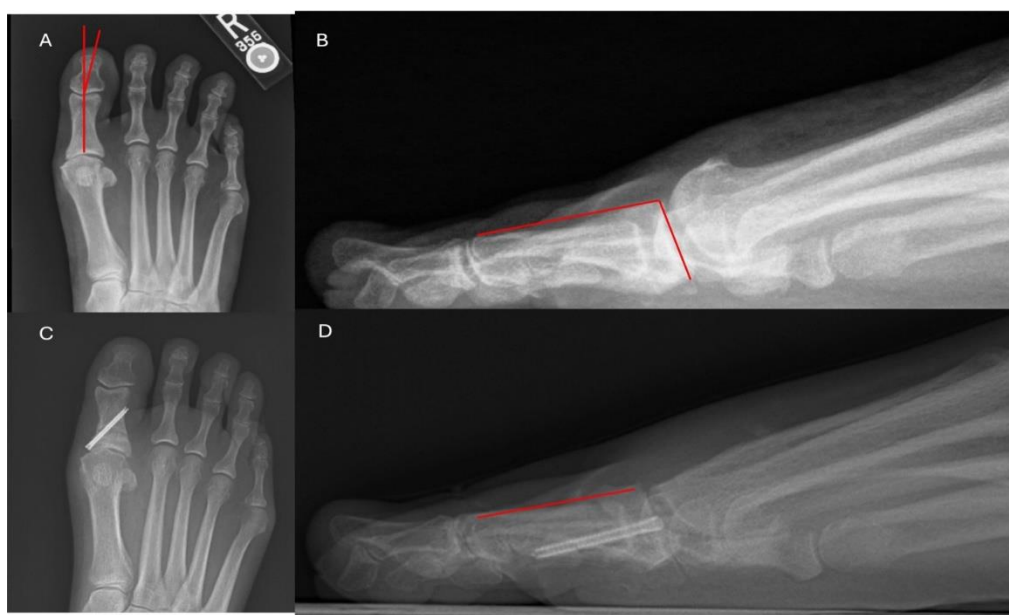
Pre- and post-operative radiographs following MIS cheilectomy/Moberg osteotomy showing the arthritic change on the AP view (A) and dorsal spurring (B). Image (A) also demonstrating the measurement for HVI. (B) Demonstrates sagittal articular P1 angle measurement. (D) Shows the post-op dorsal cortical length measurements. Images C and D also show the alignment of the screw fixation
